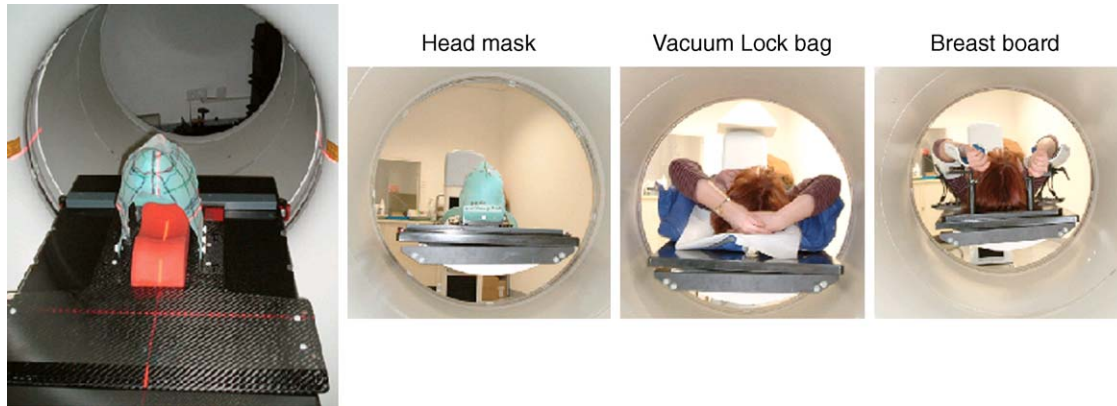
Positioning aids for radiation therapy patients, which can be used in conjunction with PET/CT tomography assuming a wide enough tunnel (70 cm and more).
